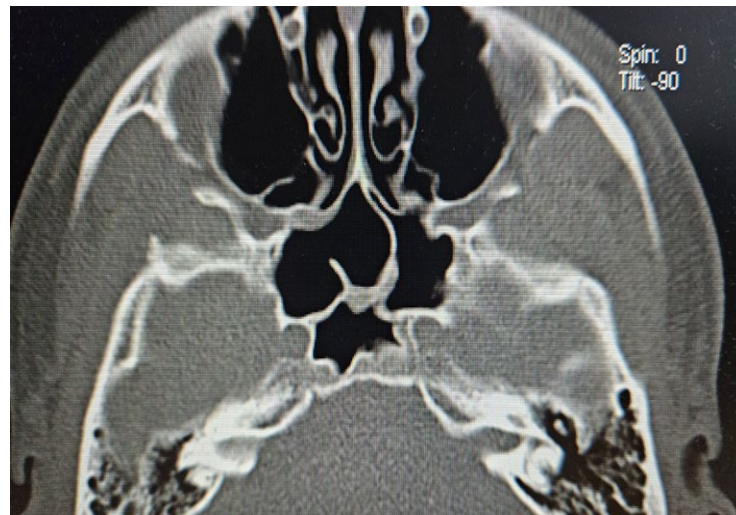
Axial CT slice of the sphenoid sinus, bone window, demonstrating two septa (one complete and one incomplete), asymmetric – a representative image for the majority of the evaluated cases*
